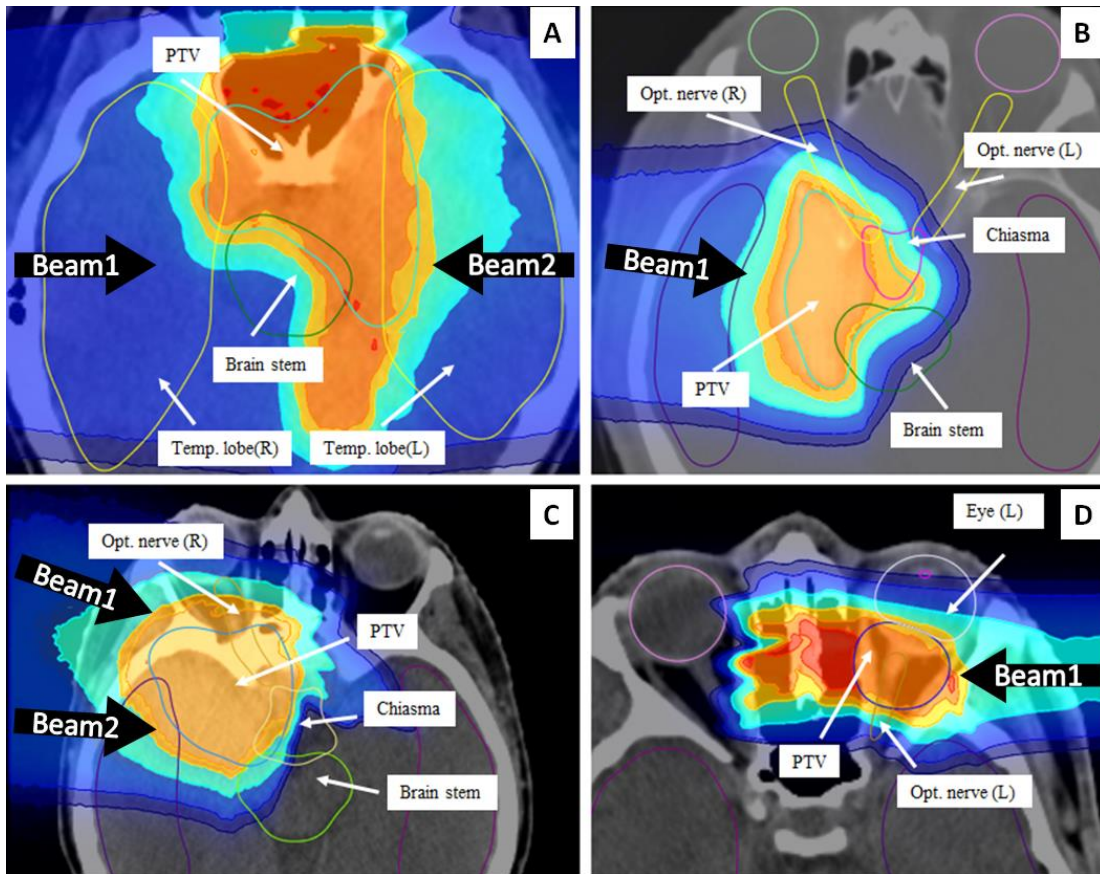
The four panels above display the complex relation between the contoured PTV and OARs for the four considered patient cases on the X-ray computed tomography axial images (gray scale) with the overlaid dose distributions (color wash) for proton plans calculated with MCTP (section 7.3.1). Second beam for patient B is not visible for this image, but can be seen in figure 7.3.
